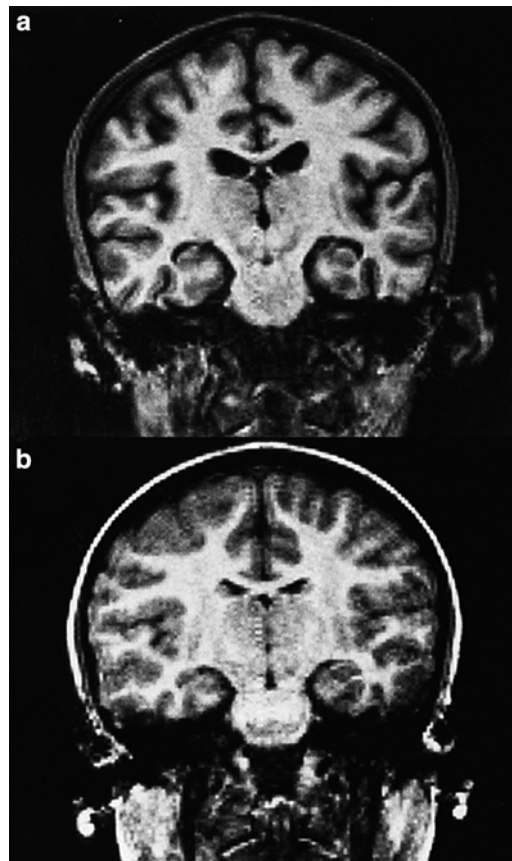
Coronal MRI image of an 11-year-old patient with anorexia nervosa (a) compared with that of an 11-year-old healthy control subject (b). (a) Sulcal enlargement and marked dilation of the third and lateral ventricles. (b) Normal anatomy at the same level. Reprinted from Golden NH, Ashtari M, Kohn MR, Patel M, Jacobson MS, Fletcher A, Shenker IR. Reversibility of cerebral ventricular enlargement in anorexia nervosa, demonstrated by quantitative magnetic resonance imaging. *J Pediatrics* 128(2), 296–301, Copyright (1996), with permission from Elsevier.
